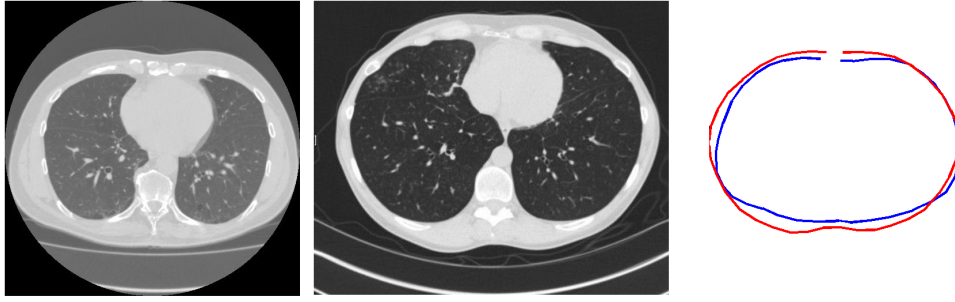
Two different CT scans of different patients and their two boundaries plotted together.
